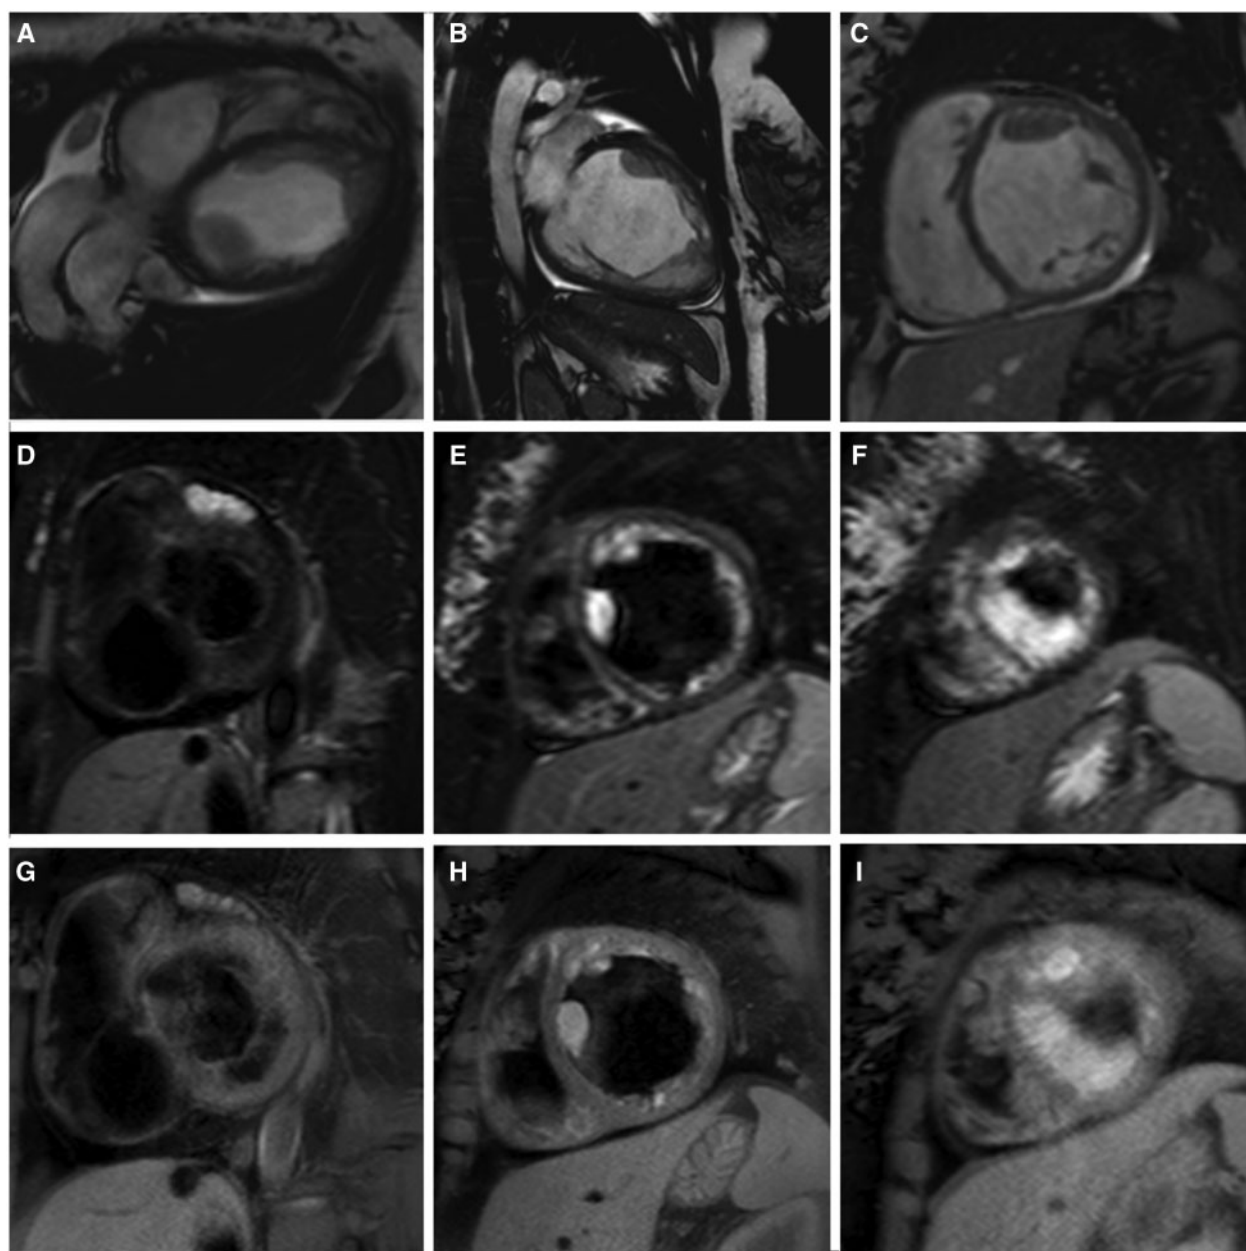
Cardiac magnetic resonance images, in horizontal (A) and vertical (B) long-axis views and in short-axis view (C) by cine Steady State Free Precession sequence. Multislice images in short-axis view from basal (D, G) to apical (F, I), by T1- (D–F) and T2- (G–I) weighted sequences, showing hyperintense signal.
